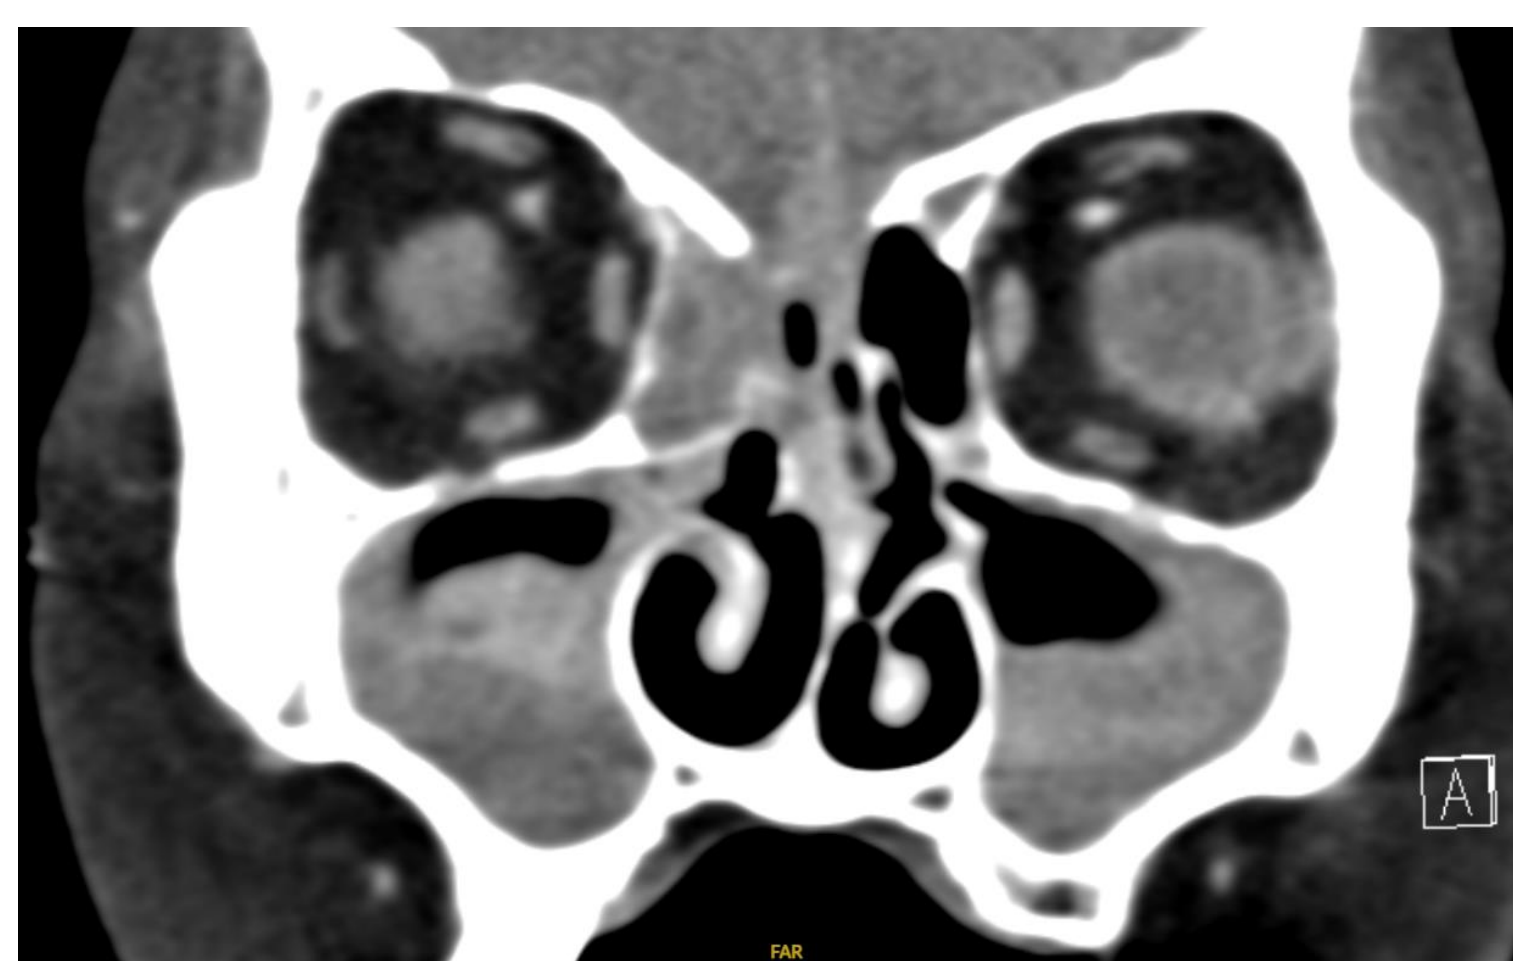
Maxillary and ethmoid sinusitis on CT sinuses scan
